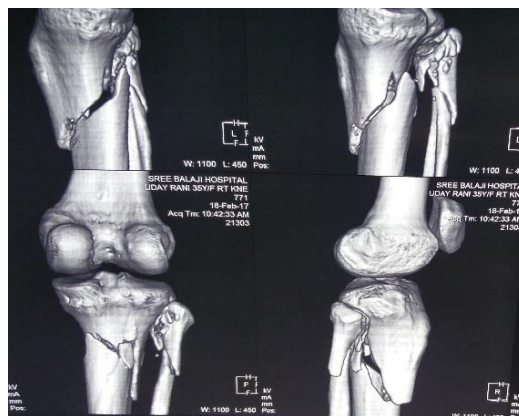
CT-Scan: confirmed no intra articular extension but close to metaphysis
